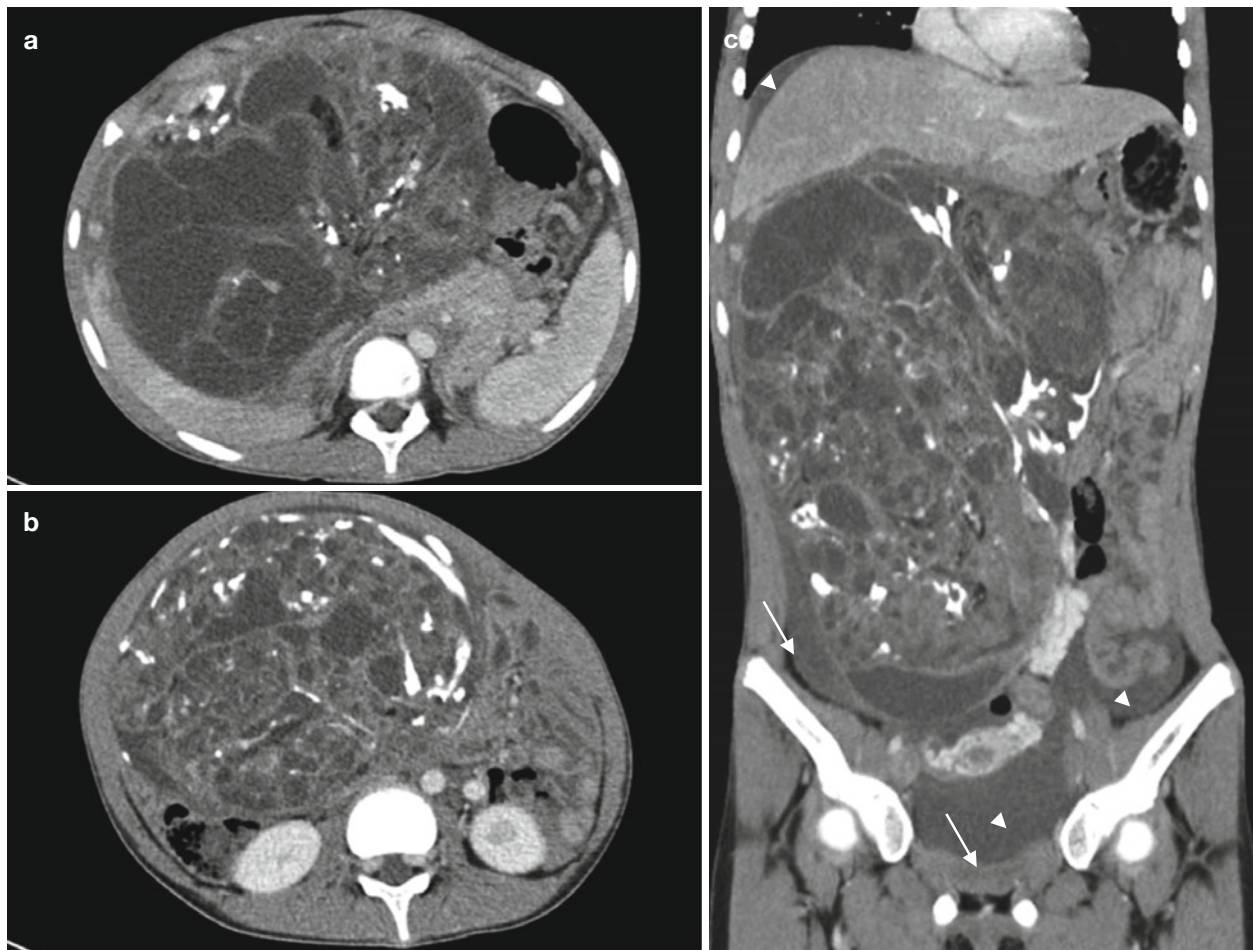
Ruptured immature teratoma in a 13-year-old girl. (a, b) Contrast-enhanced CT scans show a huge, predominantly solid mass containing fat and calcifications filling the abdomen and pelvic cavity.
